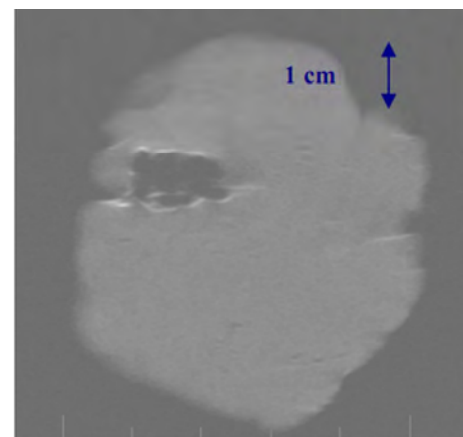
MRI image using T1-w FSE of large boiling lesion created *in vitro* using 2000 W/cm^2 for 20 s.
